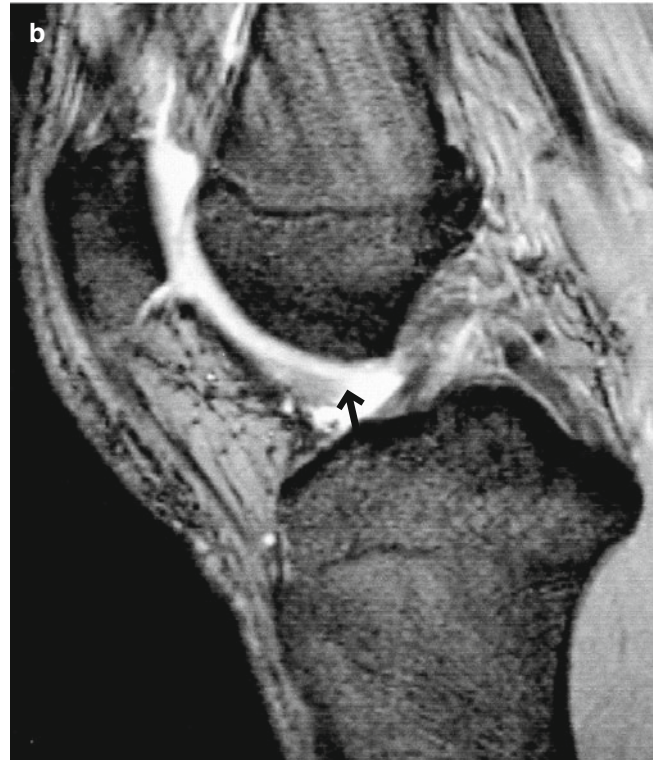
Infrapatellar plica. A man in his late teens. (a) Arthroscopic image and (b) T2WI. There is a band-like structure just anterior to the ACL, representing infrapatellar plica (IPP). In sagittal MRI, it can rarely be visualized as a thin band-like structure running in front of ACL in parallel to it (arrow)
